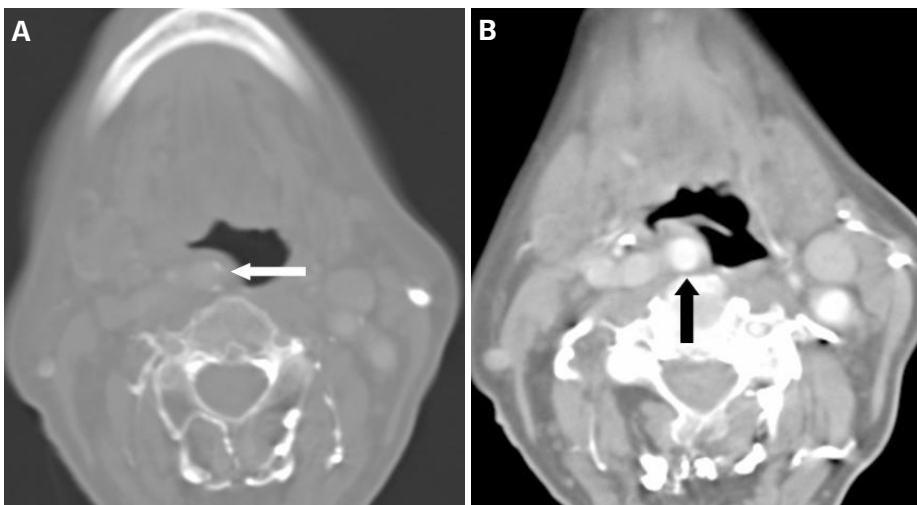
(A) Axial postcontrast CT examination (at the soft tissue window) shows tortuous common carotid artery bulging the pyriform sinus and indenting epiglottis at the level of the right hypopharyngeal wall (black arrow). There is minimal expansion in the orbit medial wall, no bone erosion is seen. (B) Axial CT examination (at the bone window) shows a few small punctate calcific foci (white arrow) in the right distal common carotid arter.
